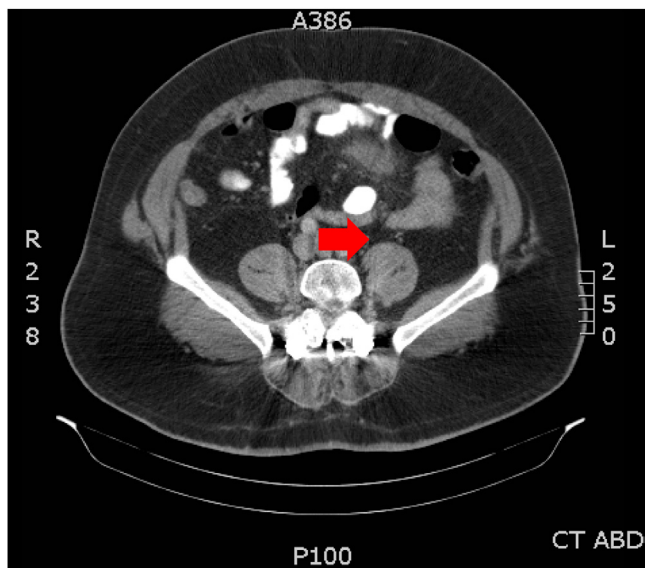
CT scan showing area of inflammation.
